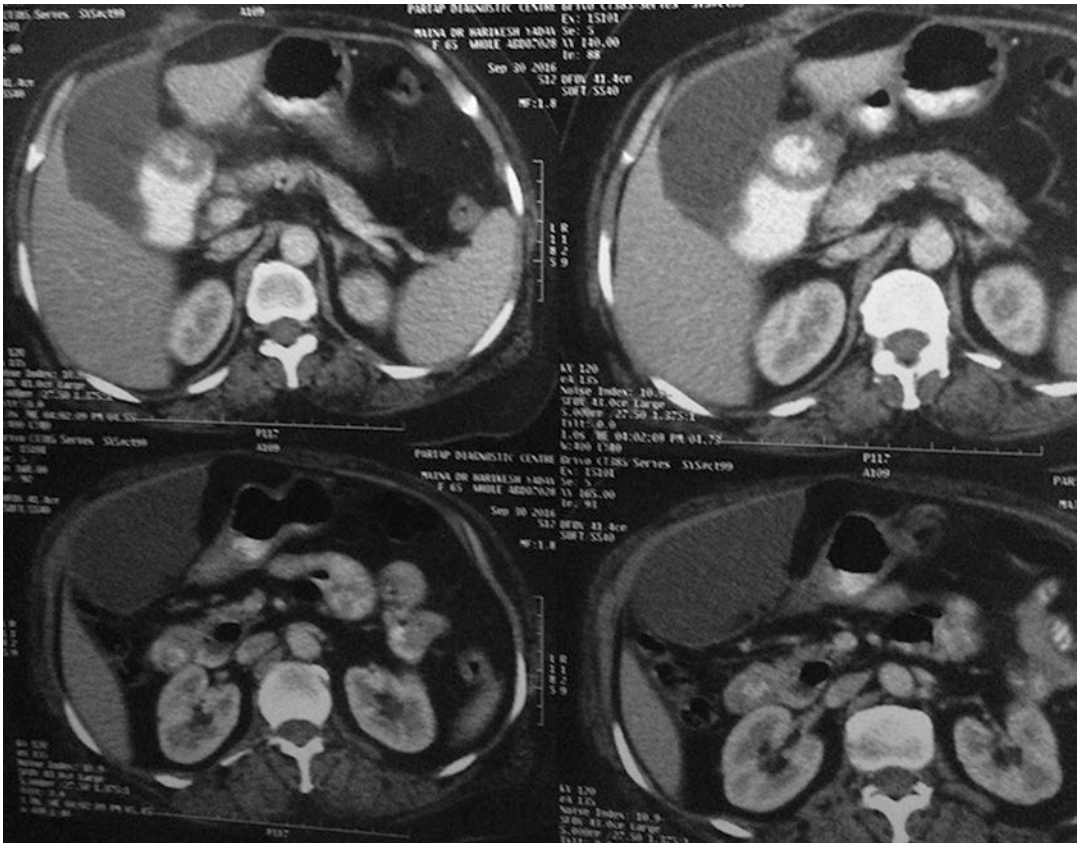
Computed tomography showing biloma
